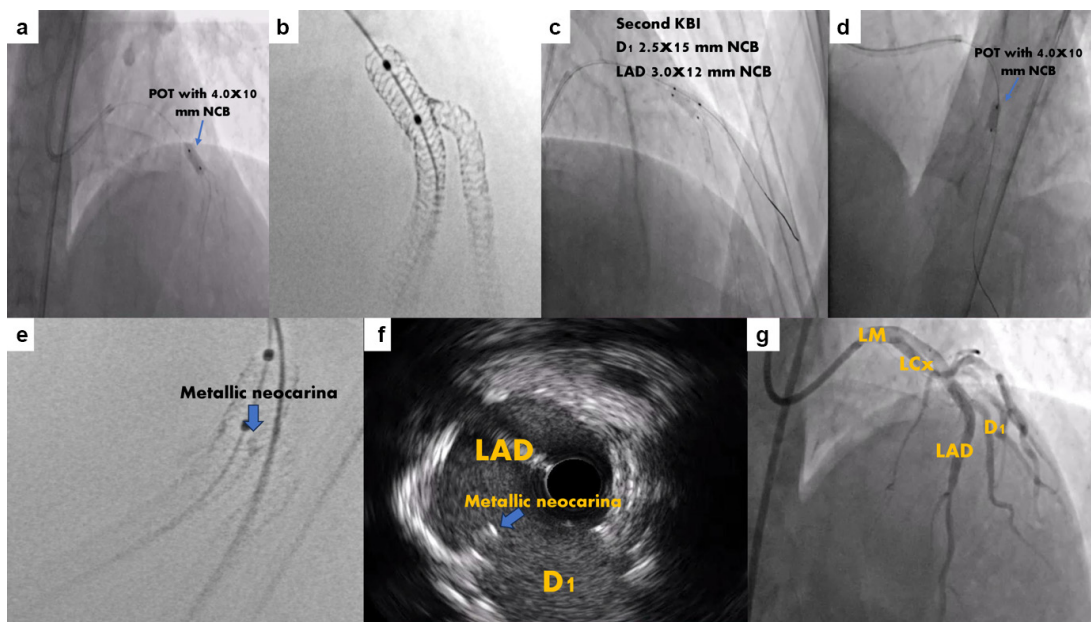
(a-d) POT, final KBI, and re-POT. (e, f) ClearStent and IVUS images showing adequate stent apposition and metallic neo-carina. (g) Final result. DES, drug-eluting stent; D1, first diagonal artery; IVUS, intravascular ultrasound; KBI, kissing balloon inflation; LAD, left anterior descending artery; LCx, left circumflex artery; LM, left main coronary artery; NCB, non-compliant balloon; POT, proximal optimization technique.
